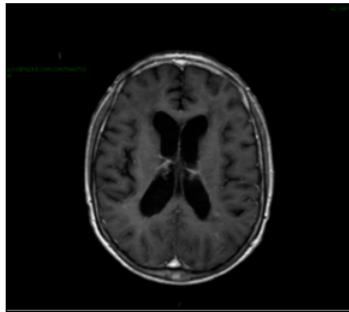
Axial post-gadolinium T1-weighted MRI.
